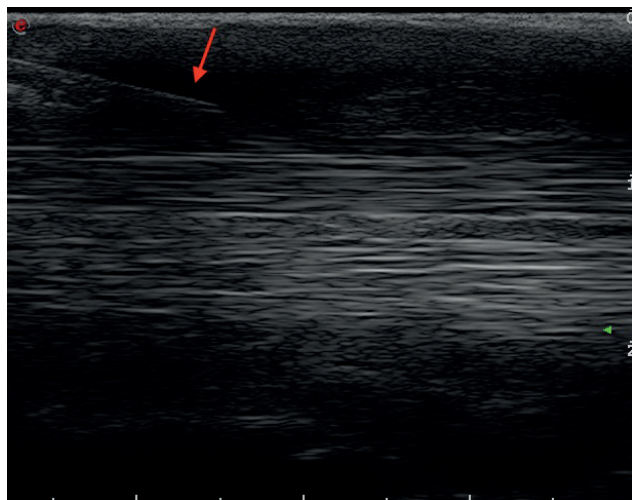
M-mode 12MHz longitudinal ultrasound image of the palmar metacarpus during injection of the superficial digital flexor tendon (SDFT). The tip of a 21G needle is evident within a marginal hypoechoic SDFT defect before intralesional injection (arrow).
